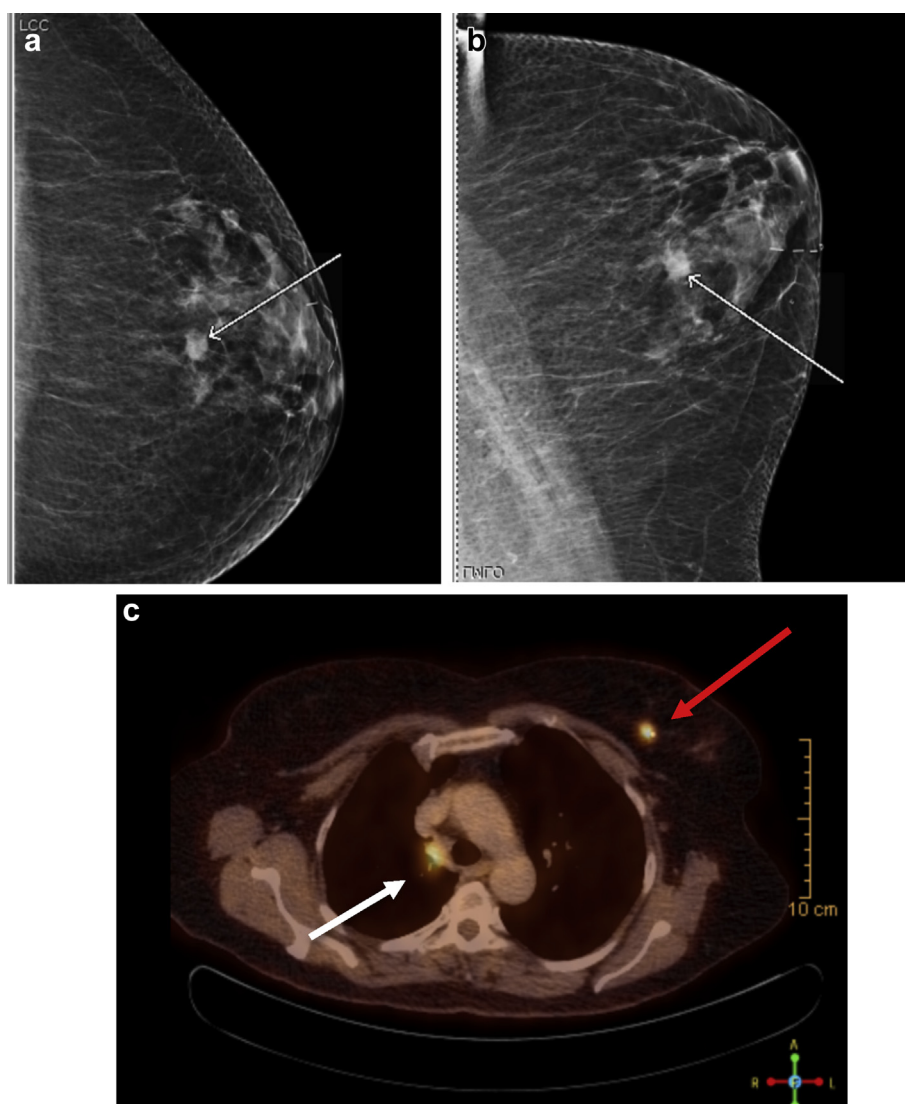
Left breast mammogram showing lesion (white arrow): (a) craniocaudal view, (b) medio-lateral oblique view, (c) positron emission tomography (PET)/computed tomography (CT) scan axial views of right paratracheal lesion standardized uptake value (SUV) 4.6 (white arrow) and left breast lesion SUV 6.4 (red arrow).
